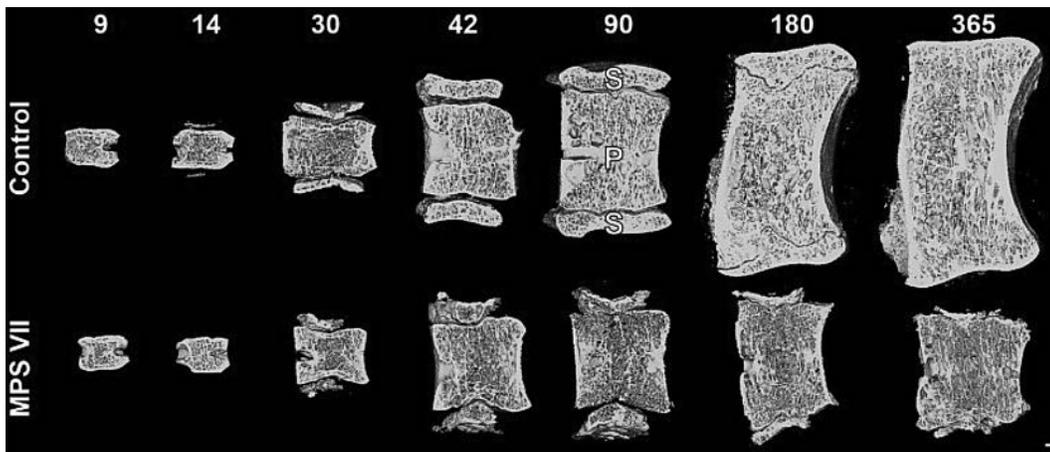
Representative midsagittal μ CT images showing lower trabecular bone content in MPS VII vertebral primary ossification centers at older ages compared to controls. Numbers indicate postnatal days-of-age. Scale = 1mm. S: Secondary ossification center; P: Primary ossification center.
